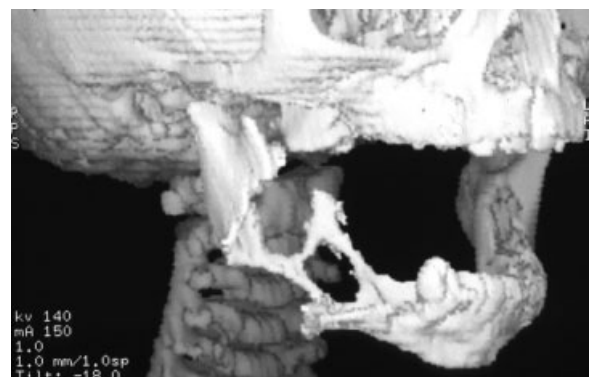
Three-dimensional computed tomographic (3D-CT) scan of a 4-month-old boy with extensive bony destruction of the right mandible.
